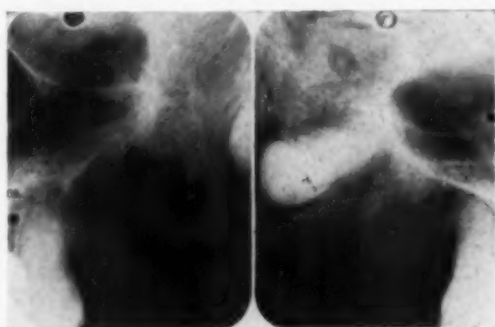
X-rays showing sockets of the abutment teeth.
